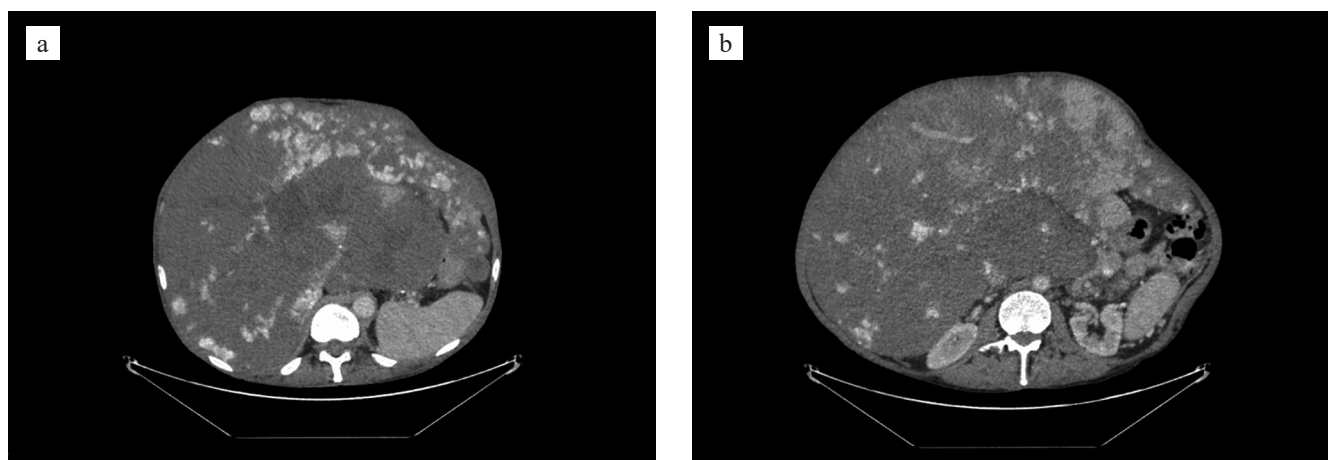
Contrast-enhanced spiral computed tomography of the abdomen and retroperitoneal space in a patient with diffuse hepatic hemangiomatosis and giant hemangiomas: a, axial section at the liver level during the arterial phase of contrast enhancement: multiple hypodense foci are visible in both lobes of the liver, some of which (>5 cm) have characteristic peripheral nodular enhancement; b, axial section at the liver level during the venous-parenchymatous phase of contrast enhancement: centripetal accumulation of contrast agent in giant hemangiomas is visualized
